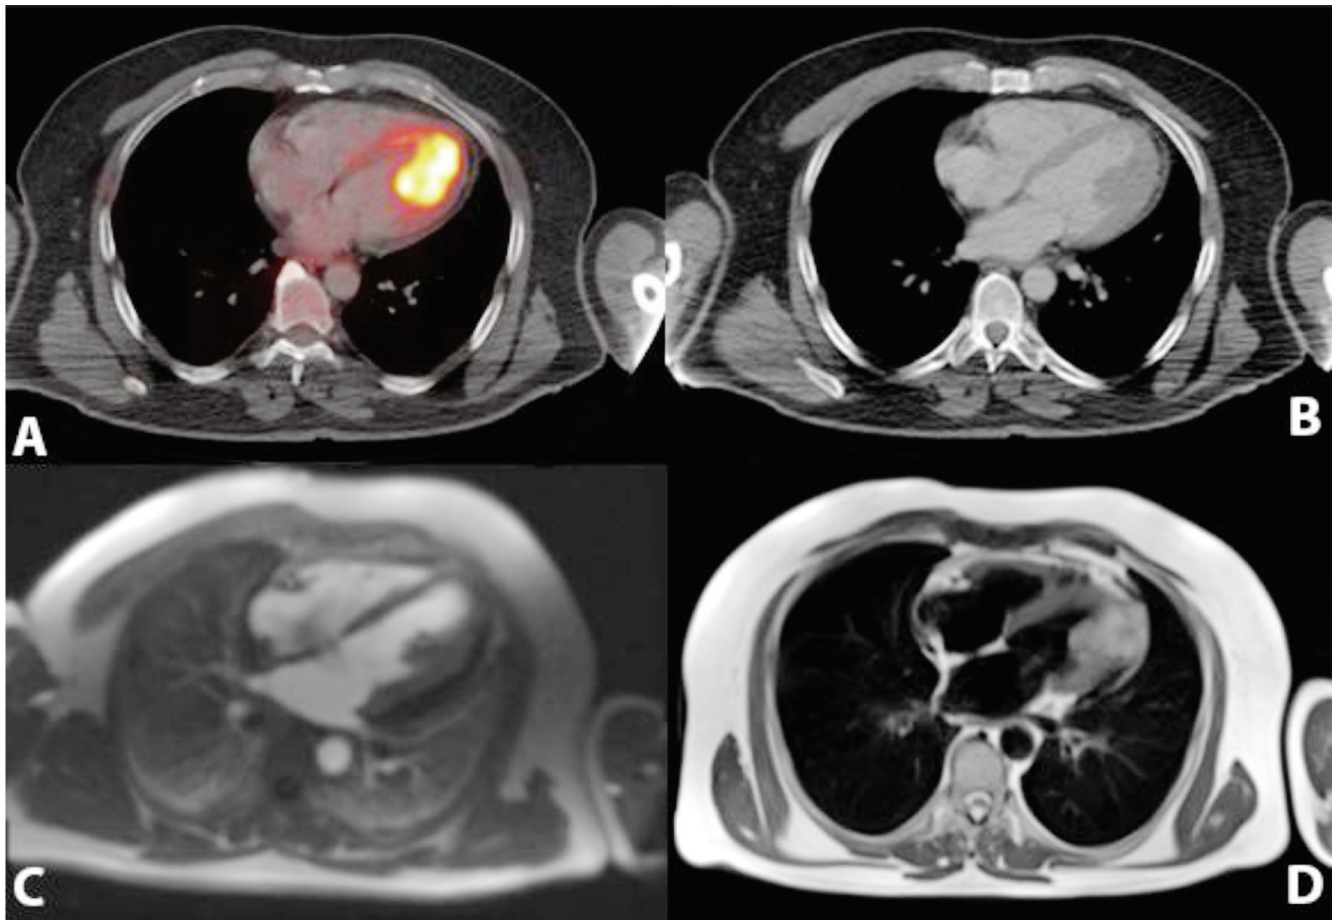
A 58-year old patient with a history of malign melanoma was referred to our PET/CT department for re-staging. Patient was initially diagnosed with excisional biopsy from the nail bed of his first left toe 4 years ago. Inguinal lymph node biopsy revealed negative for metastases at the time of diagnosis. Metastatic lymph nodes were detected in left inguinal region which was confirmed with biopsy 3 years later. Patient was under immunotherapy and had no symptoms either in the control or in the day of scan.
